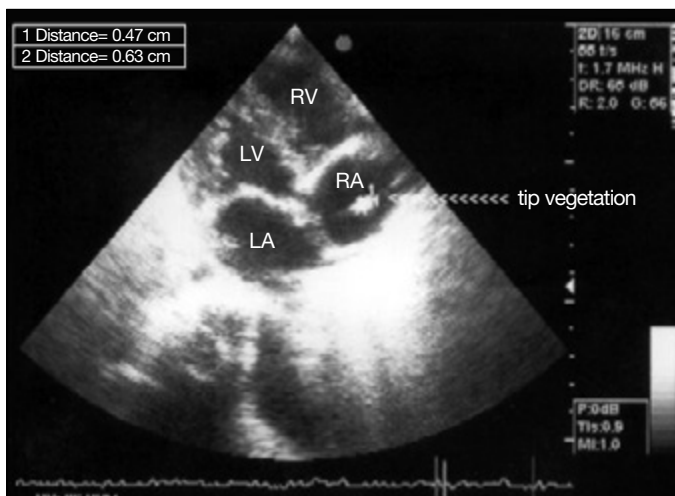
Echocardiography-tip vegetation
